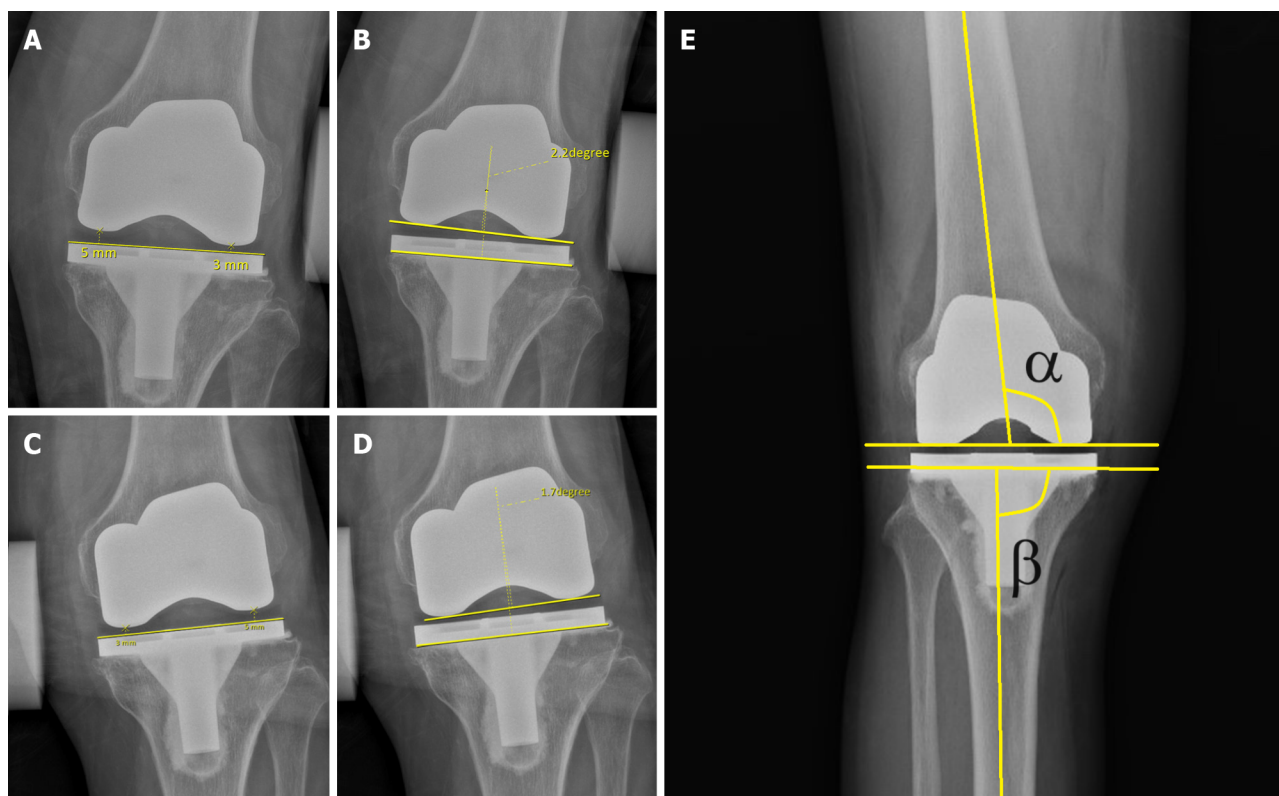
Measurement methods used in this study. A: The valgus gap opening distance was measured by subtracting the medial gap from the lateral gap on the stress radiograph; B: The valgus gap opening angle was determined based on the angle between the line of the tibial tray and the line of the most distal part of the femoral component on the stress radiograph; C: The varus gap opening distance was measured by subtracting the lateral gap from the medial gap; D: The varus gap opening angle was determined based on the angle between the line of the tibial tray and the line of the most distal part of the femoral component; E: The alpha (α) and beta (β) angles of the femoral and tibia components on the antero-posterior radiograph.
